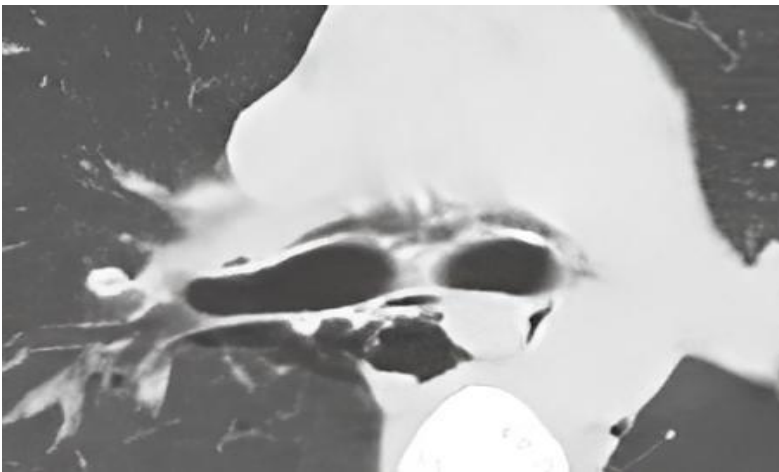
Grade 2 pneumomediastinum: Mediastinal air extending inferiorly down to the level of the carina on an axial CT image
